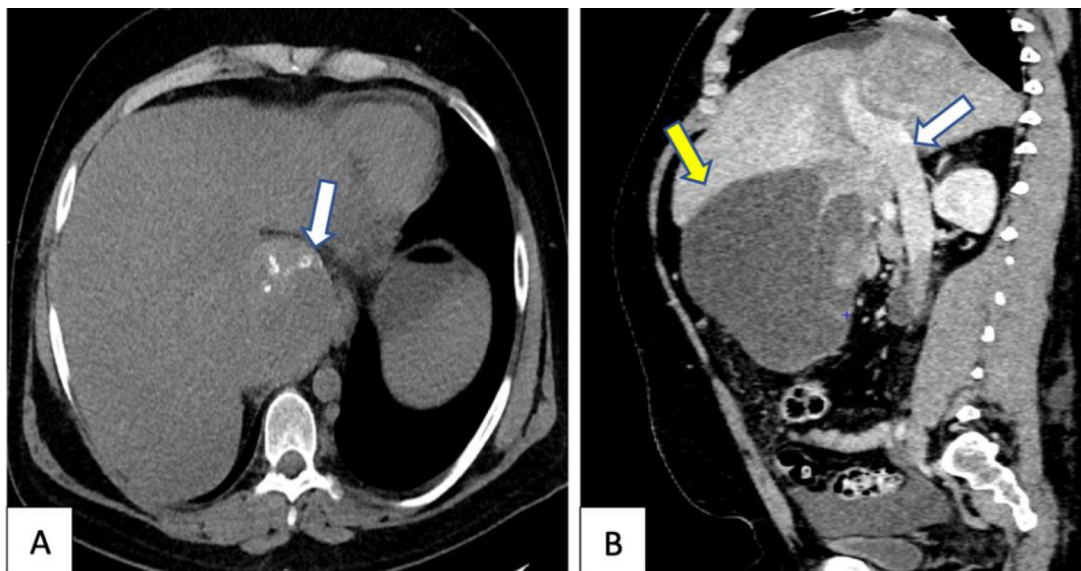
Pre-injection axial plane computed tomography (A) shows naturally hyperdense calcifications within the tumor (white arrow, image A). The venous phase sagittal plane (B) shows that the mass contacted the inferior vena cava but does not cause stenosis of the vessel lumen as well as thrombosis, the fluid-like hypodense part of the tumor compresses on the liver parenchyma but shows no signs of invasion (yellow arrow, B).
